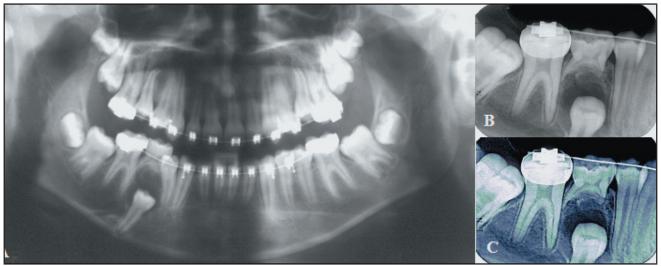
Panoramic (a), periapical conventional (b), and digitized electronically processed (c) radiographs revealed a unilocular, well-defined, radiolucent lesion surrounding the unerupted right inferior second premolar's crown and involving the right inferior primary second molar's apex. Note the radiolucent area showing an undefined margin.
